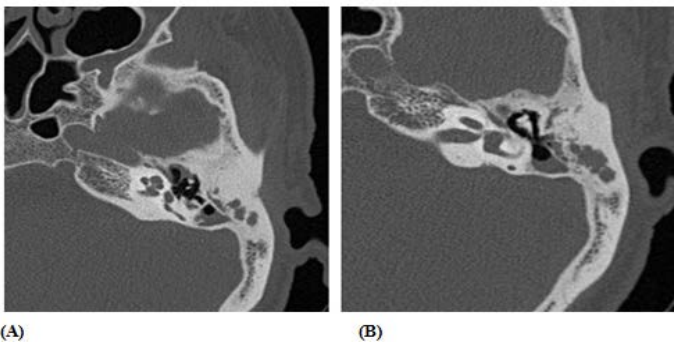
(A) and (B) Axial HRCT images showed Soft tissue thickening is seen in right middle ear and mastoid air cells, mastoid septations are Eroded. No cortical breach is seen. Intact facial nerve canal and No destruction of middle ear ossicles is seen, s/o safe variety of CSOM
